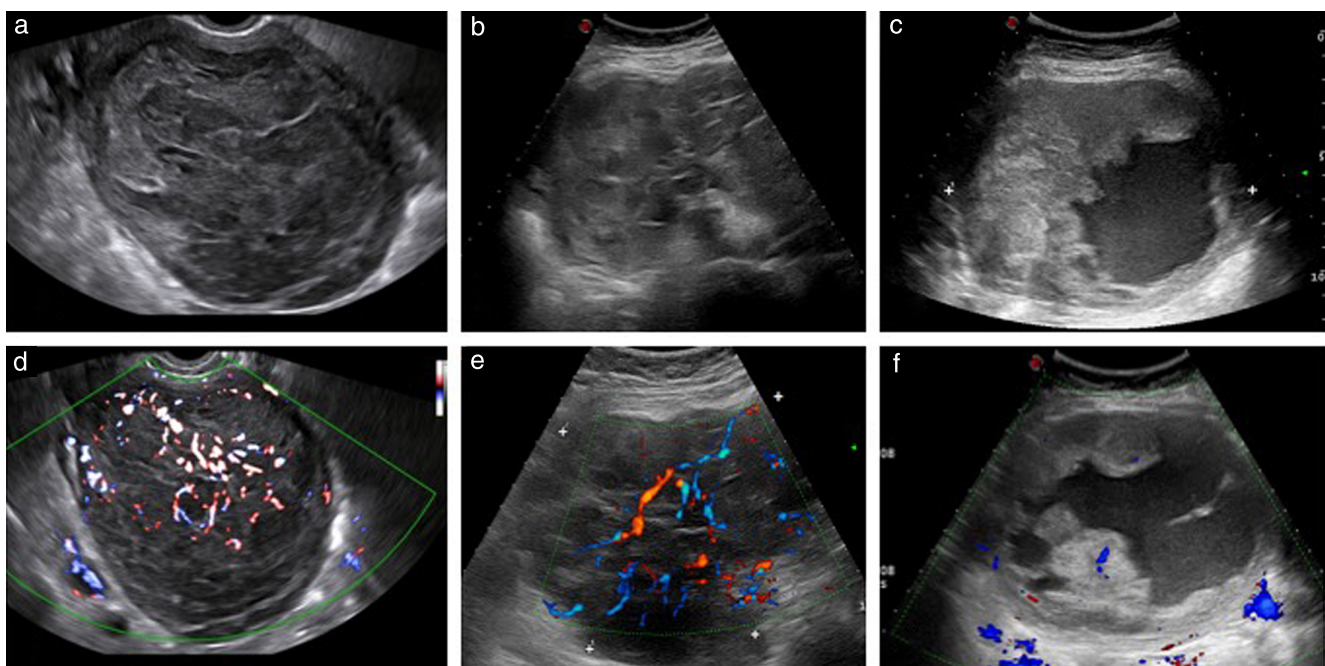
Ultrasound images of uterine sarcomas. According to assessment by original examiner, there was normal visible myometrium (yellow arrows) in 149/195 (76.4%) cases (a,c), 151/195 (77.4%) sarcomas manifested inhomogeneous echogenicity of solid tissue (a,b,d), 87/195 (44.6%) contained cystic areas (c), 103/195 (52.8%) had irregular tumor borders (b) and 127/187 (67.9%) manifested moderate or rich vascularization (d).
